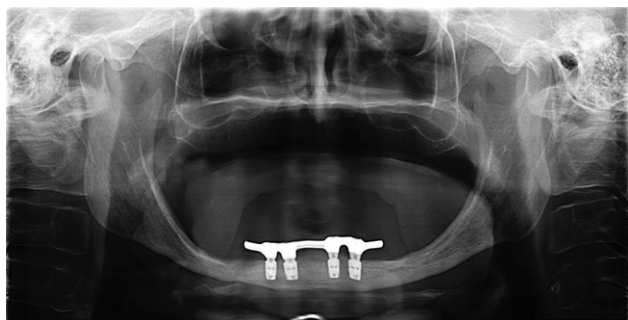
Panoramic radiograph of the same patient as in Figure 1 with bar-supported overdenture 1 year in function.
